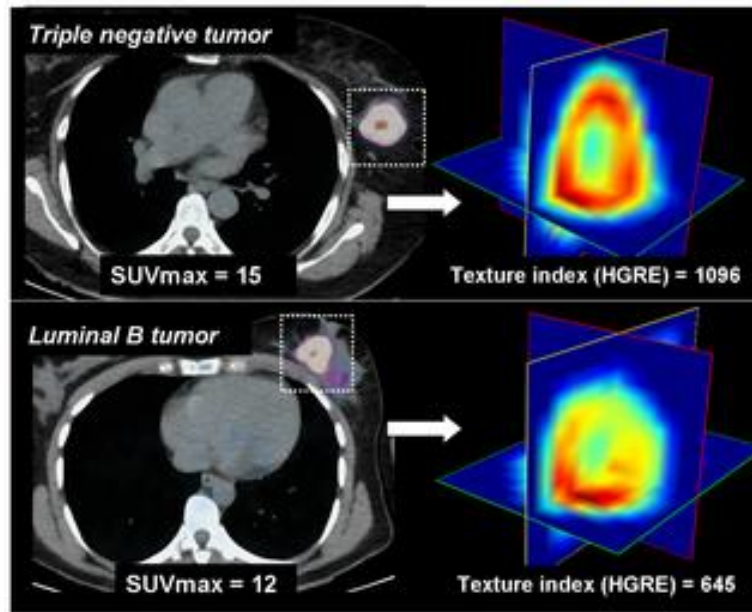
High-Gray-level Run Emphasis (HGRE) textural feature calculations for different breast tumours. A triple negative tumour shows higher SUV than a more aggressive luminal B tumour. Nevertheless, HGRE can correctly classify the tumours. Figure is reproduced from (Soussan et al., 2014).
